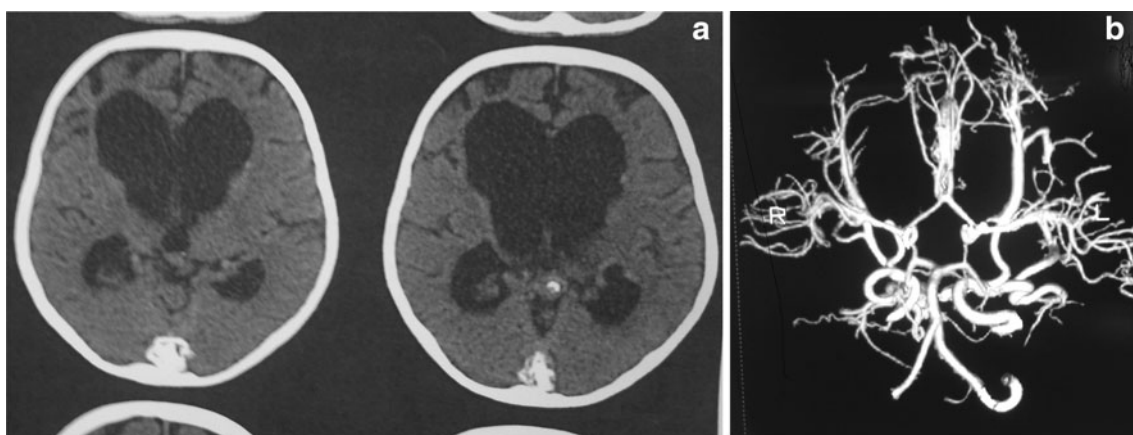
a Brain CT scan after 3 years confirms calcified thrombosis inside the torcula and Galen which corresponds to the previous severely dilated torcula and aneurysmal malformation of Galen. b CT angiography reveals complete regression and disappearance of the aneurysmal dilatation of Galen
